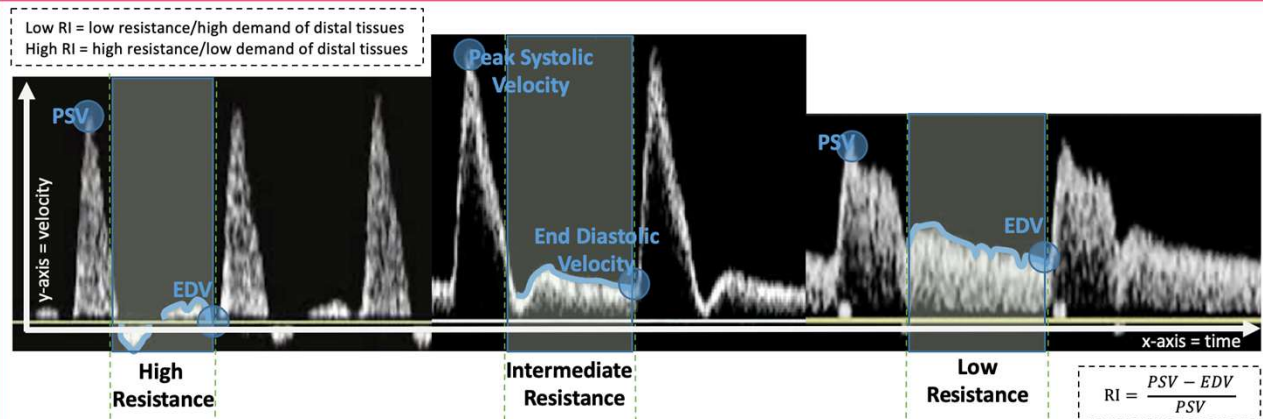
Arterial spectral Doppler waveforms demonstrating varying levels of resistance.<sup>6</sup>
